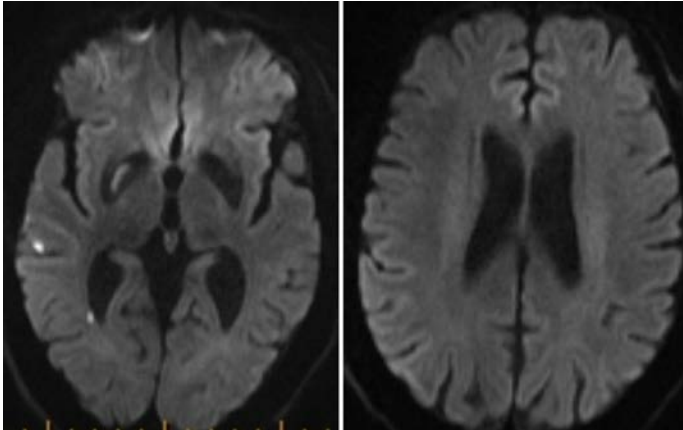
Magnetic resonance imaging at 24 hours.
